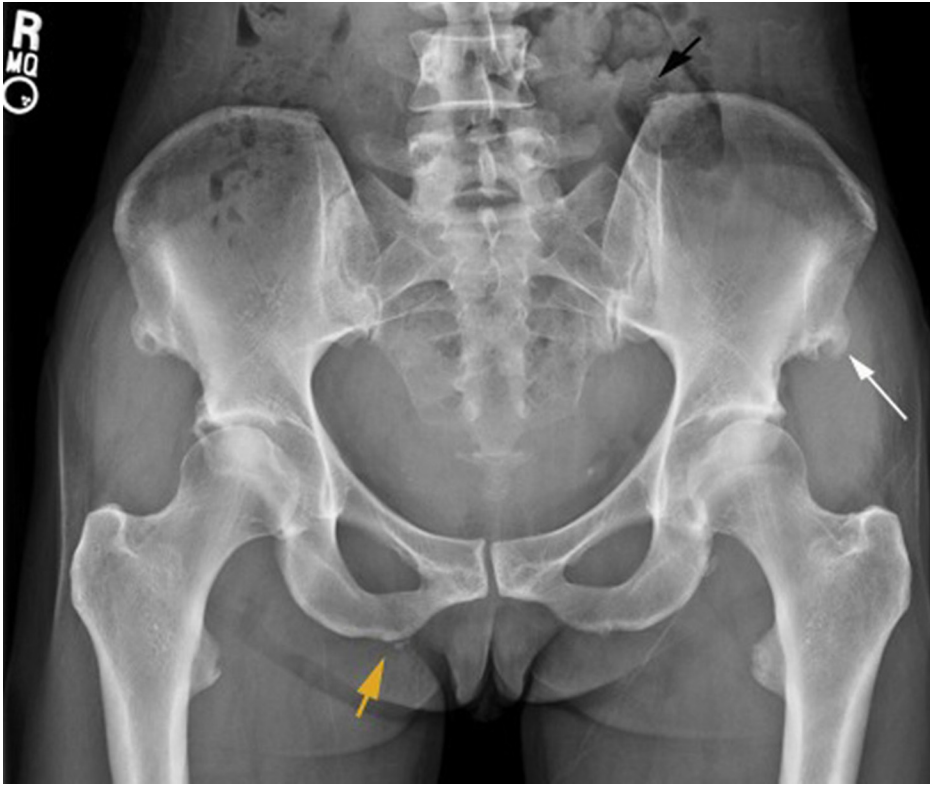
49-year-old woman with retinoic acid arthropathy. AP radiograph of the pelvis shows enthesopathy at the iliolumbar ligament insertions (black arrow), anterior superior iliac spines (white arrow), and hamstring tendon (yellow arrow) attachments bilaterally.
